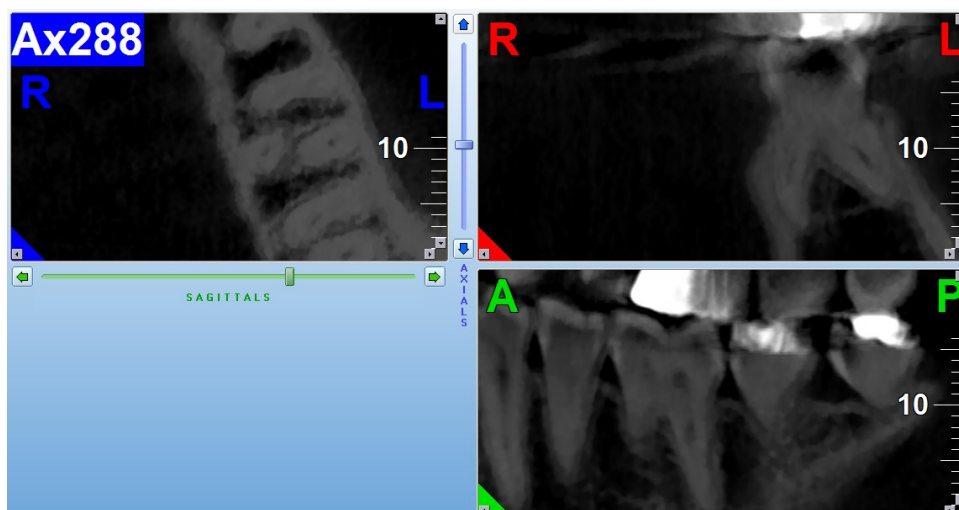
Axial, coronal and sagittal view of CBCT image, showing Radix entomolaris
